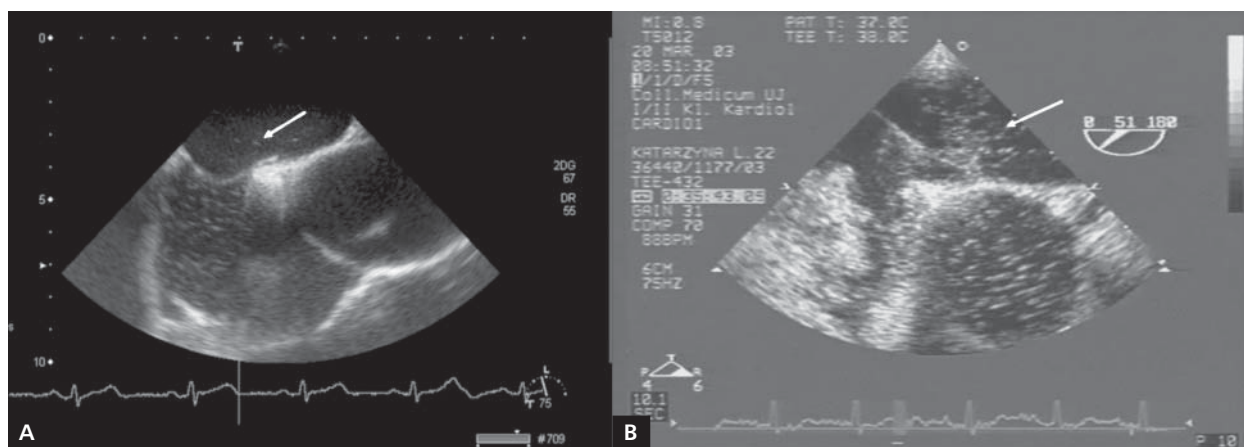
Transoesophageal echocardiography using agitated saline contrast. Longitudinal biatrial/bicaval view. A. Passage of single contrast bubbles from the right to the left atrium is seen (arrow). B. A large amount of contrast bubbles can be seen passing from the right to the left atrium (arrow)
